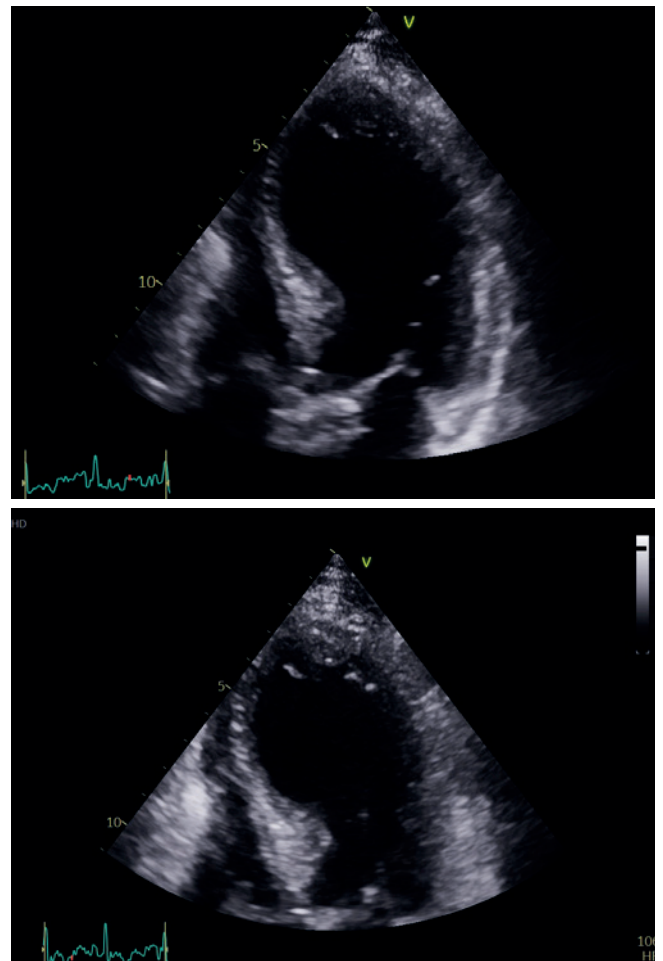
Apical 4 chamber image showing apical akinesia with preserved basal segments contraction suggestive of Takotsubo/stress cardiomyopathy.
